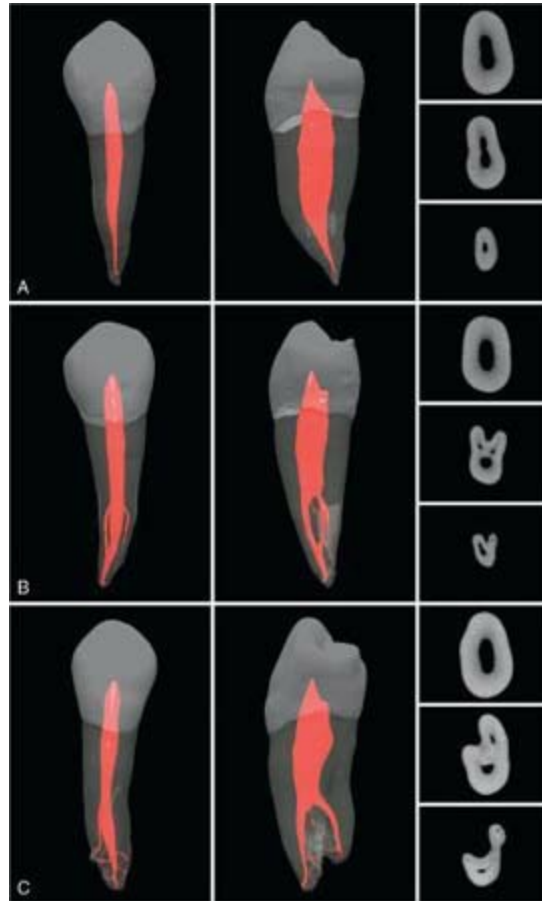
μ CT scans of mandibular first premolars. A, Common anatomic presentation. B, First premolar with significant canal deviations in the middle to apical third before returning to a single large canal apically and a small deviating canal to the proximal. C, First premolar with a branching main canal lingually and multiple accessory canals. All teeth are shown from both a buccal (vestibular) and a proximal perspective, along with the cross-sectional anatomy at the coronal, middle, and apical levels. (See Video 7.15 online at the Expert Consult site for rotational views of these teeth.)
